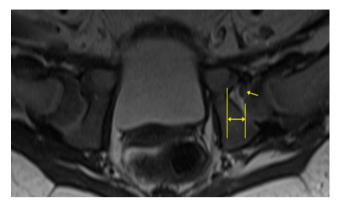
Transverse T2-weighted MR image of hips in a 5 month old girl with dysplastic left hip, following closed reduction. Note the wide fat pad (horizontal arrow) and the low-signal barrier to reduction (arrow: inverted labrum and thickened transverse ligament). This hip failed initial spica casting and required subsequent open reduction.
